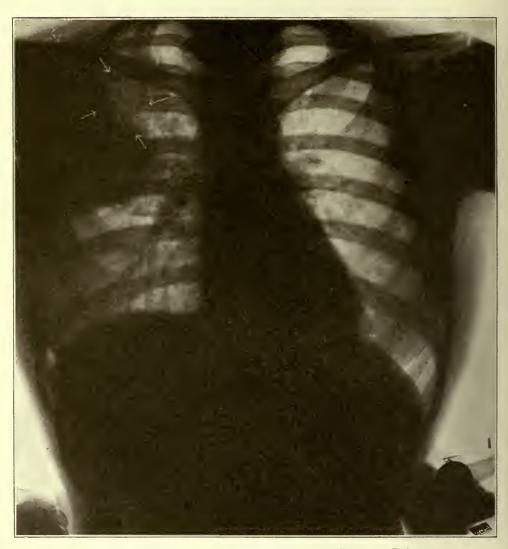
Roentgenogram of chest of woman, aged 27 years. Pulmonary abscess of right upper lobe. Severe cough with profuse foul expectoration began 8 days after cholecystotomy under ether anesthesia. Intermittent productive coughing paroxysms. Bronchoscopic treatment began 6 months after onset of suppuration. In the lower portion of the upper lobe, there is seen a large area of exudate which is not adequately drained. Arrows surround the cavity.
